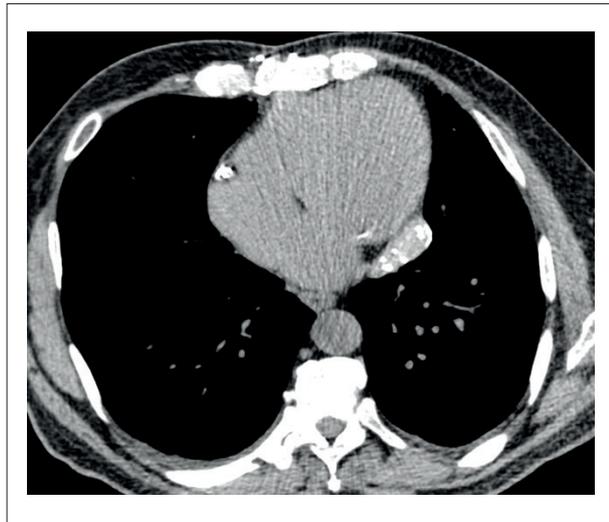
A 65-year-old man in follow-up after myocardial revascularization. Chest tomography without venous contrast shows a paracardiac mass on the left (white arrow), showing density with soft parts and a linear hyperattenuating component inside, of undetermined nature. After performing a CT-guided transthoracic biopsy, the diagnosis of a foreign body (gossypiboma) was confirmed.
